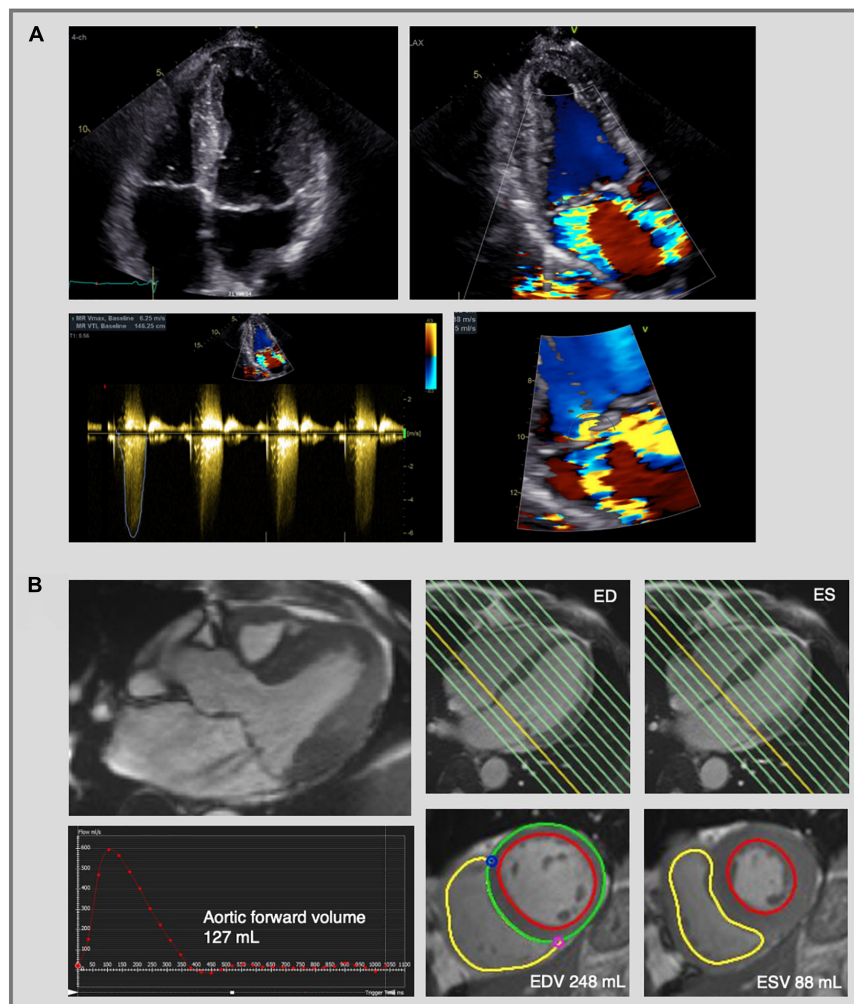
Mitral regurgitation assessment by echocardiography and cardiac magnetic resonance imaging. Complex evaluation of moderate-severe mitral regurgitation (MR) with multiple jets in a patients with bileaflet mitral valve prolapse. (A) 2D transthoracic echocardiography using color flow Doppler shows two MR jets—an eccentric jet toward the intra-atrial septum and a jet toward the lateral wall. The PISA radius was measured at 8 mm, but given the multiple and eccentric jets, this parameter is not reliable to calculate the EROA and MR volume, which indicates the need for further evaluation using CMR. (B) CMR images of the same patient as in panel (A). Three-chamber cine image shows the presence of MR with two jets (upper left image). MR volume was calculated at 33 mL using the indirect method based on the difference between LV stroke volume (EDV—ESV = 160 mL) and aortic forward volume (127 mL). The LV stroke volume was calculated from the short-axis cine images in end-diastole and end-systole (lower right images) and the aortic flow was calculated by phase-contrast imaging (lower left image). Traditionally the LV base is defined at the level of the mitral valve annulus (yellow line, upper right images) and therefore the calculated regurgitant volume includes both the transvalvular MR volume and the prolapse volume. MR, mitral regurgitation; PISA, proximal isovelocity surface area; EROA, effective regurgitant orifice area; CMR, cardiac magnetic resonance imaging; LV, left ventricle; ED, end-diastolic; ES, end-systolic; EDV, end-diastolic volume; ESV, end-systolic volume.
